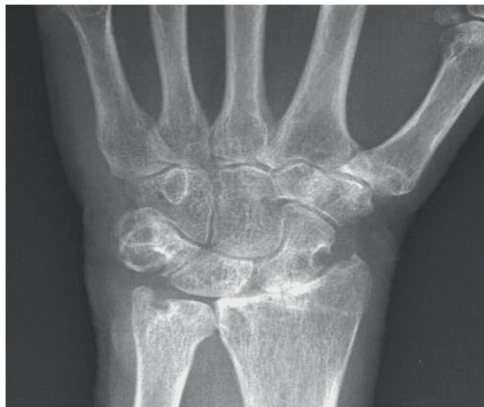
RHEUMATOID ARTHRITIS – X-RAY WRIST AND METACORPOPHALANGEAL JOINTS - Bony erosion seen in this figure.
